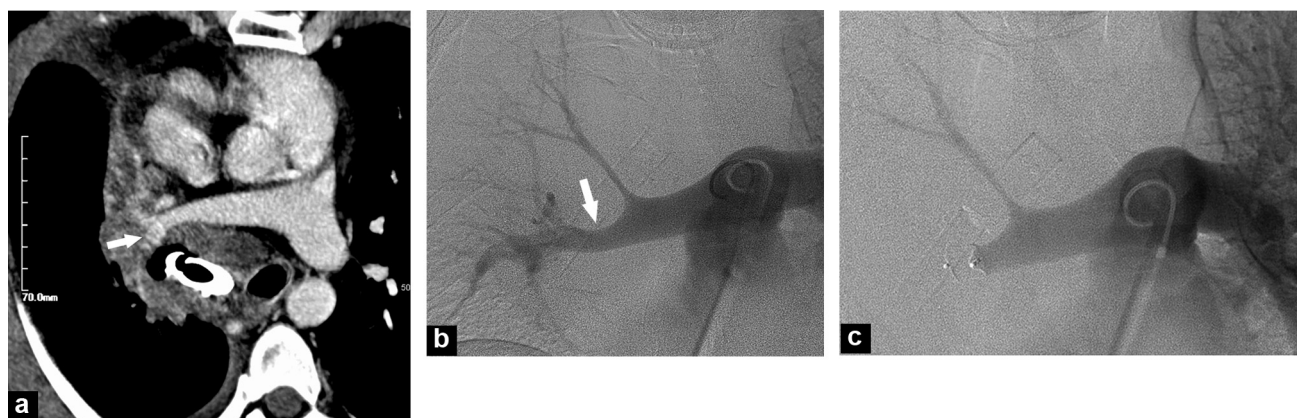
Severe hemoptysis not controlled by medical and endoscopic treatments in a patient with hepatocellular carcinoma with lung and mediastinal metastases: a: enhanced chest CT: cavitating hilar mass in contact with a interlobar artery near its border (arrow); b: pulmonary arteriography: laminar appearance of the interlobar artery (arrow); c: result after obstruction of the interlobar artery with an Amplatzer 12-mm diameter Plug.
